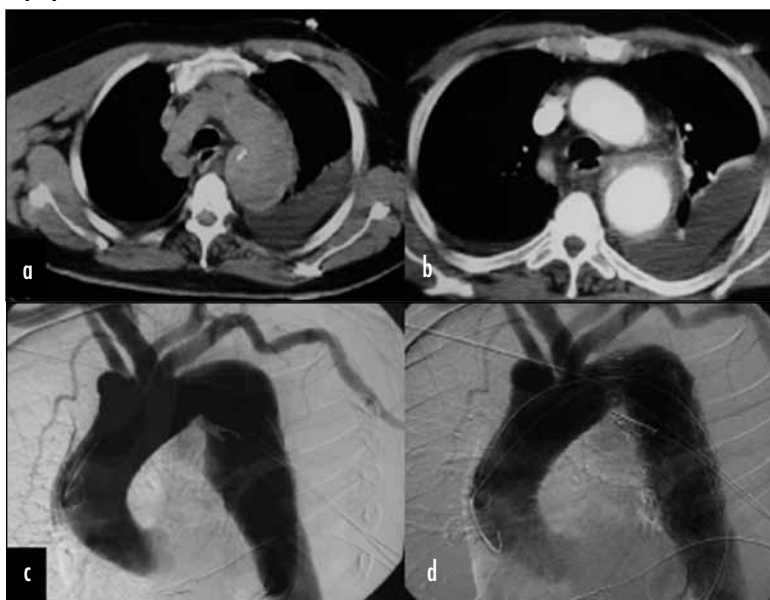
Intramural haematoma. a. Computed tomography scan plain image and (b) with contrast enhancement showing an intramural haematoma of the descending thoracic aorta. c. Conventional angiography images (c) before and (d) after stent graft deployment.
